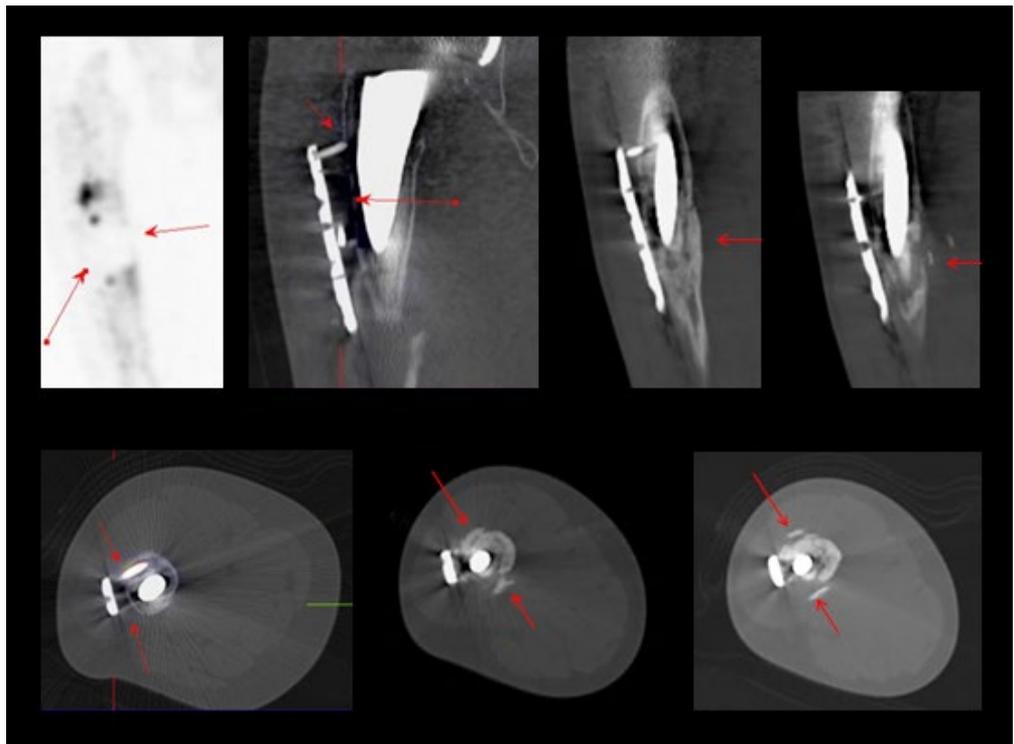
CT images demonstrate the gap between the fixation plate and edge of the femoral component of the prosthesis are secondary to loosening and extrusion as well as the bony sclerosis and periprosthetic fracture fragments at the level of the lower part of the femoral component shaft, which appears avascular on SPECT.
